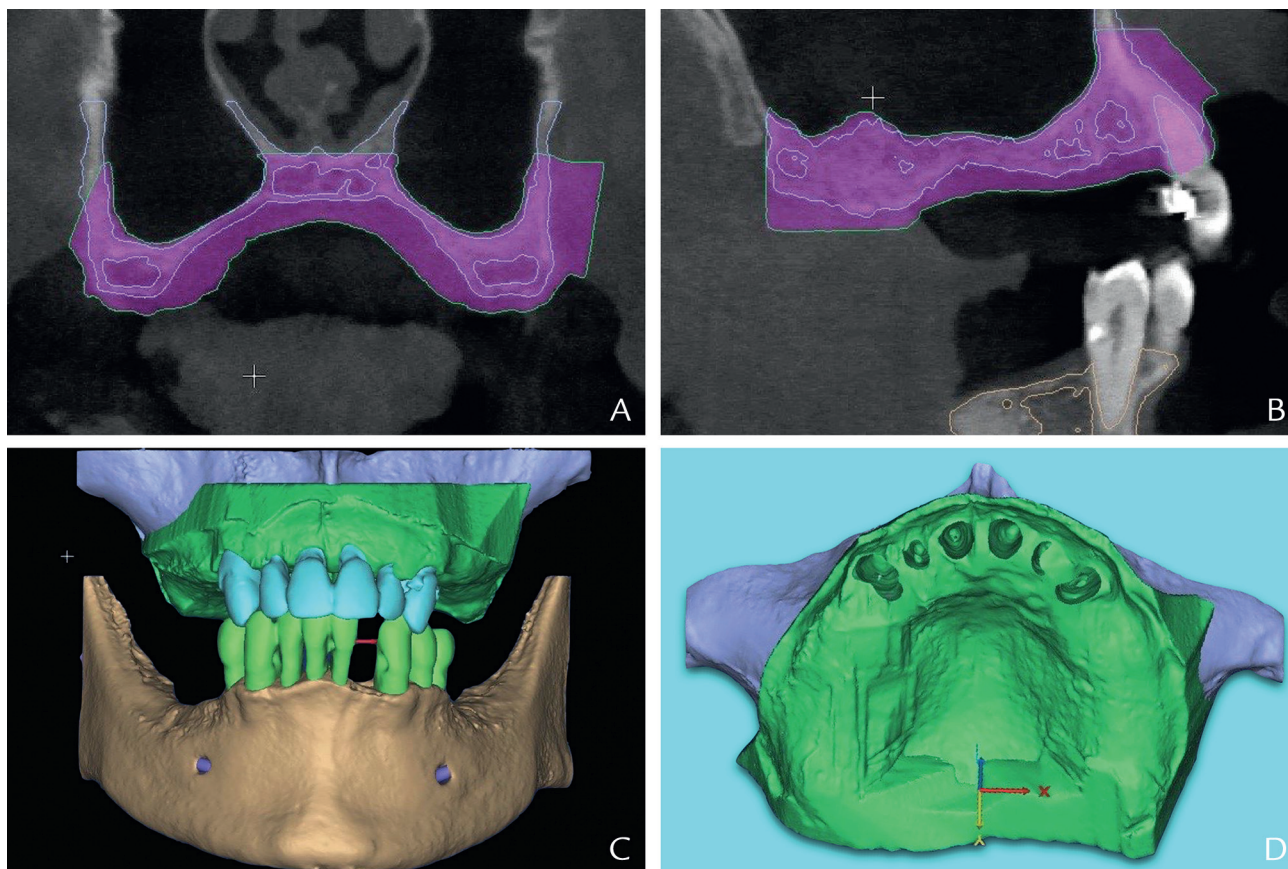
Identification of soft tissue outline from cone beam computed tomography volumetric data. A, Coronal view. B, Sagittal view; virtual diagnostic cast with segmented remaining dentition and reconstructed soft tissue profile. C, Facial view. D, Occlusal view.
